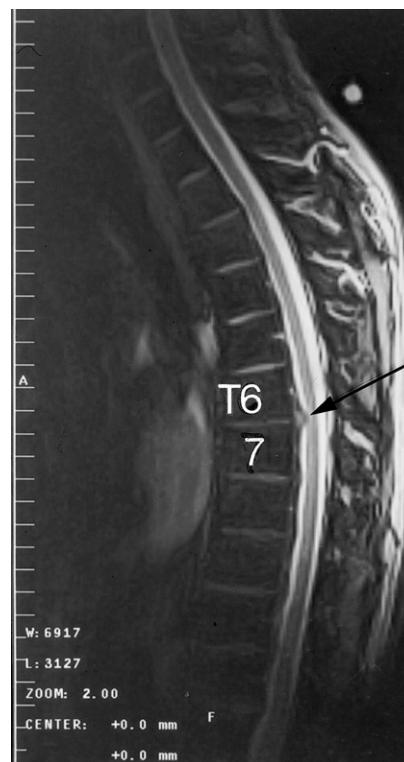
Thoracic spine MRI sagittal T2-weighted scan showing a focal posterior disc protrusion at T6–7 with impression on the thoracic cord.
